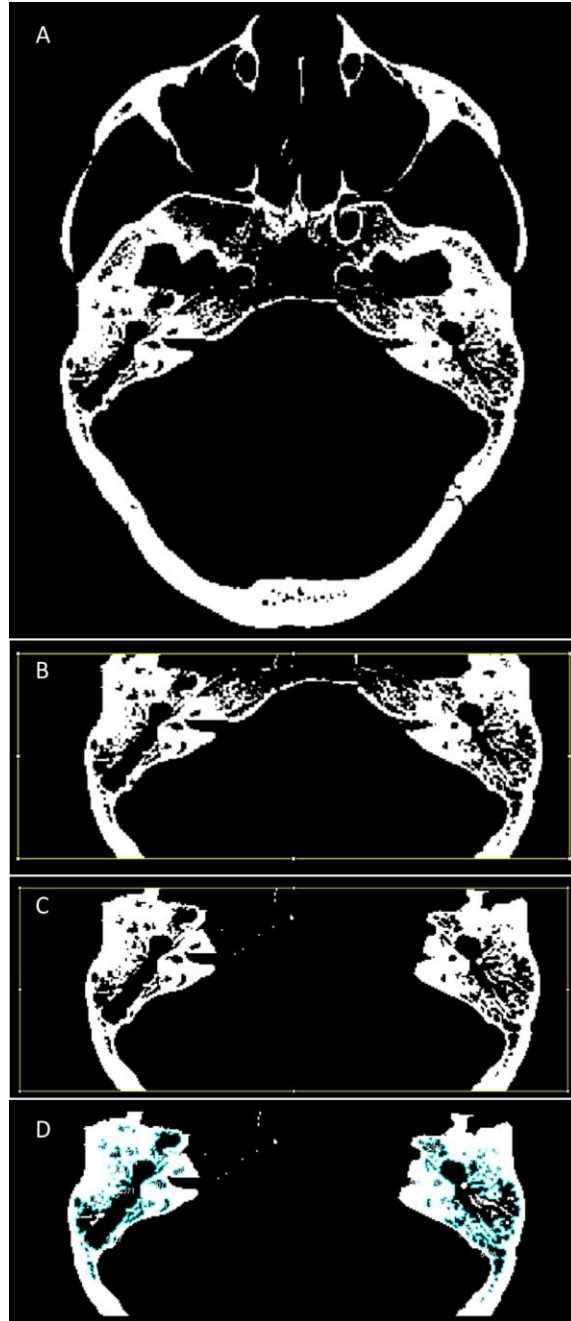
Inferior view of a CT scan slice (A) with the MACS sectioned out (B and C) and an overlay showing the area included in the MACS total volume (D)
